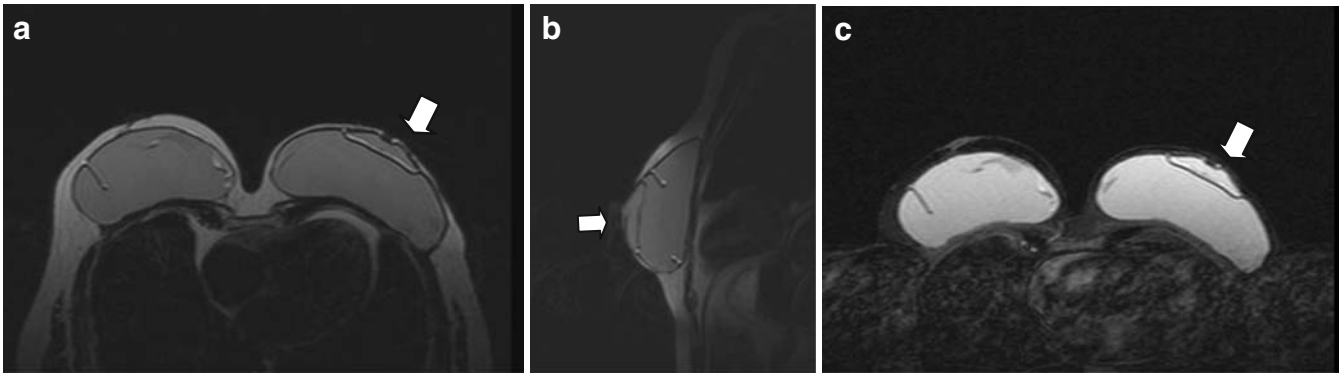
Case number 3951 of November 23th, 2005; 51 year-old patient, left radical mastectomy in 2002 and breast reconstruction with expander in 2003; the expander was changed by two implants on the left side and one was included on the right side; T2-weighted sequences in the transverse (A) and sagittal (B) plans, and T2-weighted sequences with fat suppression in coronal (C) plan showing the left breast reconstruction with 2 implants, the smallest specific for the nipple reconstruction (white arrows).
